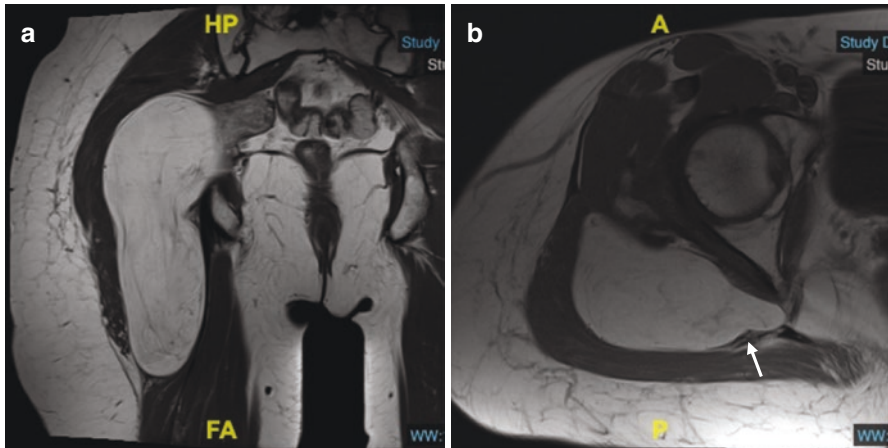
T1-weighted (a) coronal and (b) axial MRI images of a well-differentiated lipoma-like liposarcoma. Note involvement of the sciatic notch, which contains the emerging inferior and superior gluteal vessels and the sciatic (solid arrow) and pudendal nerves
